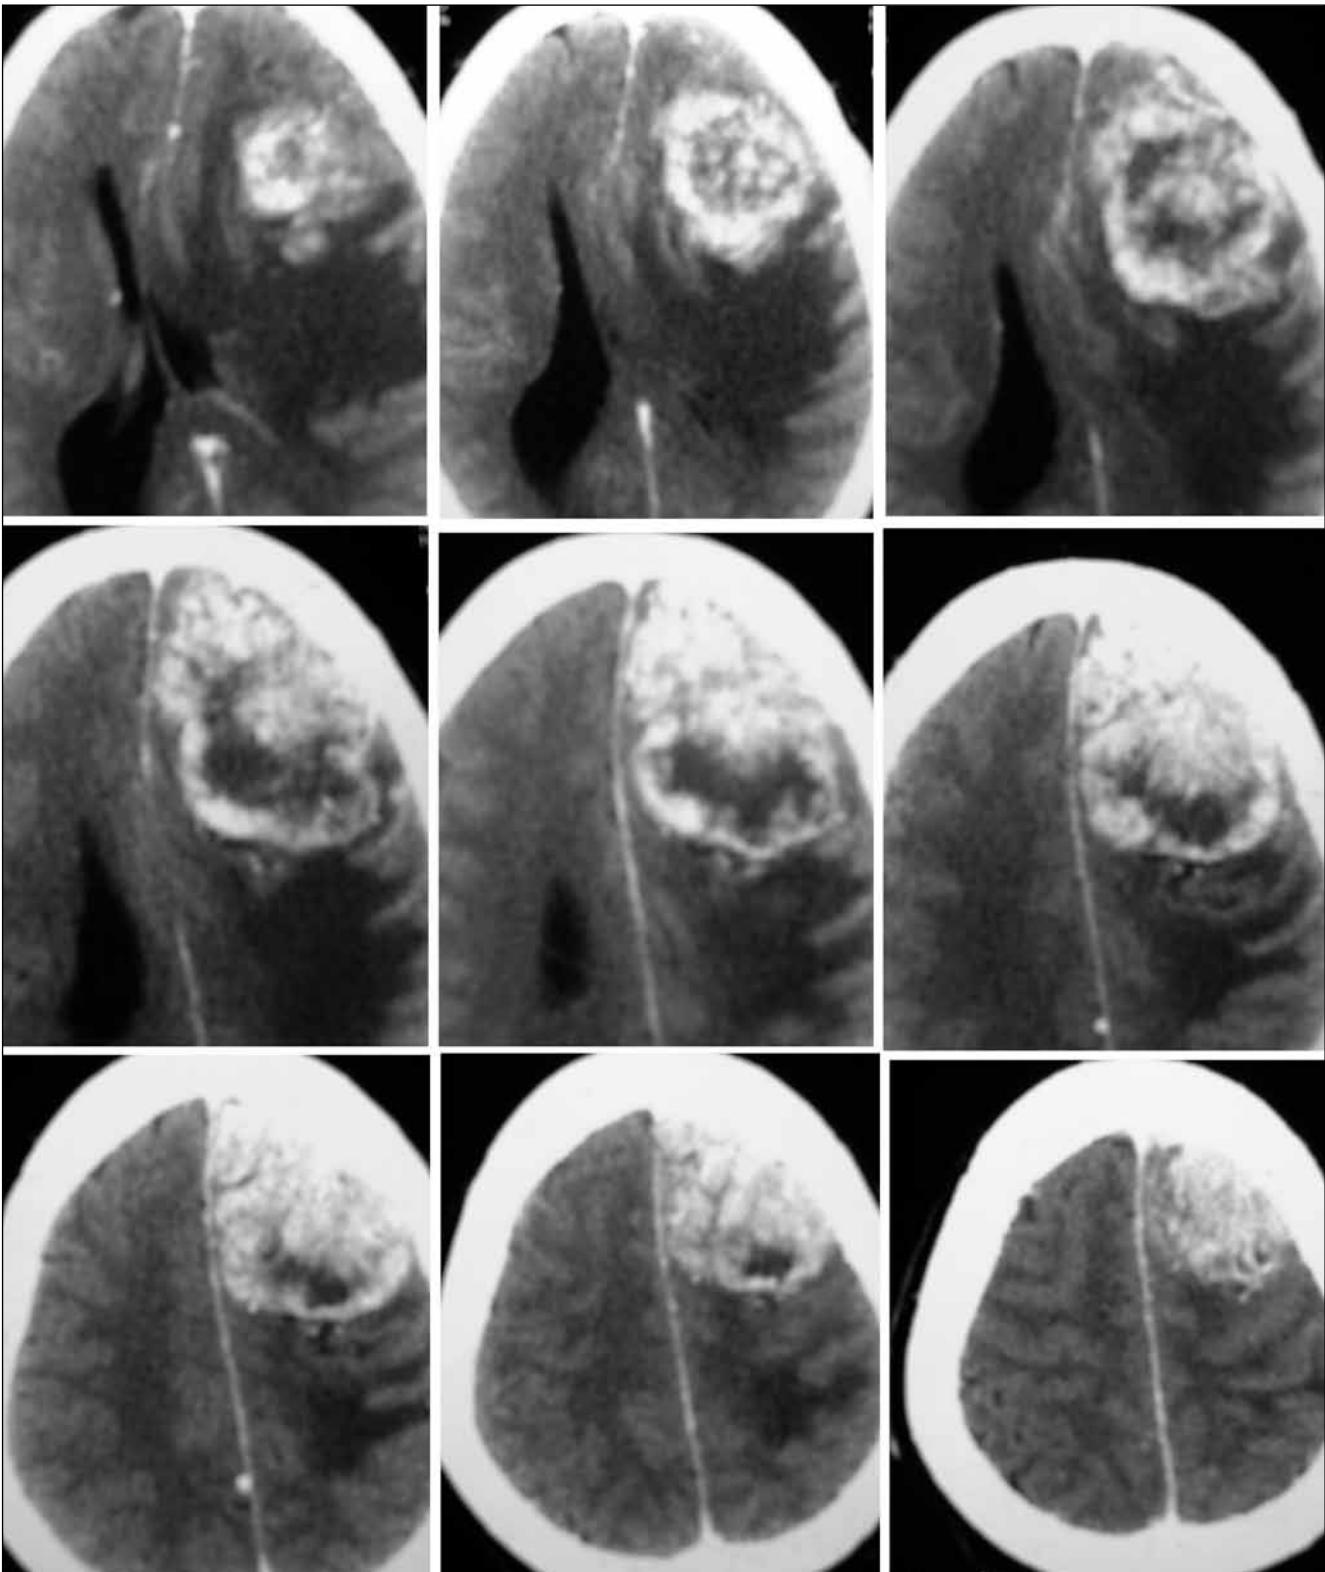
Preoperative axial CT scan of case 10 showing large left frontal meningioma.
